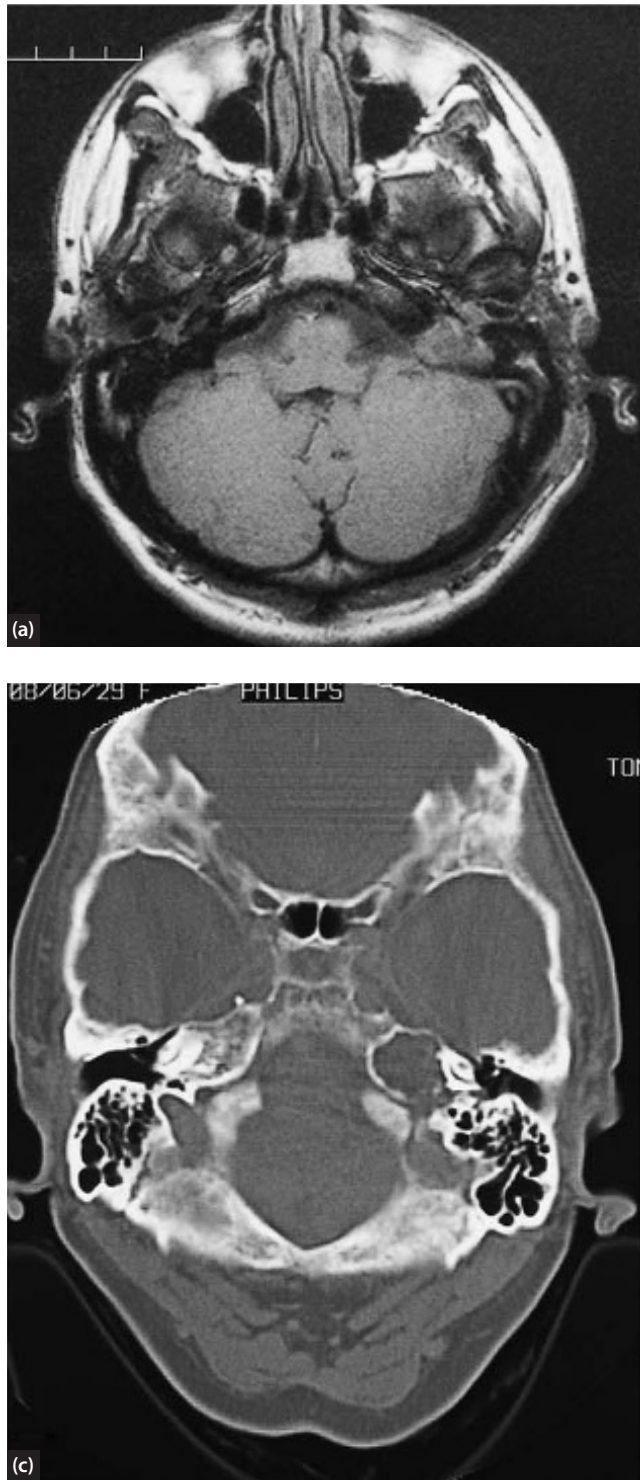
Characteristic features of left-sided, apical epidermoid cyst. (a) T1-weighted image with low signal from the petrous apex lesion; (b) T2-weighted image with high signal from the petrous apex lesion; (c) Bone-windowed CT scan showing well demarcated destruction of the left petrous apex indicative of a slow growing benign lesion.
